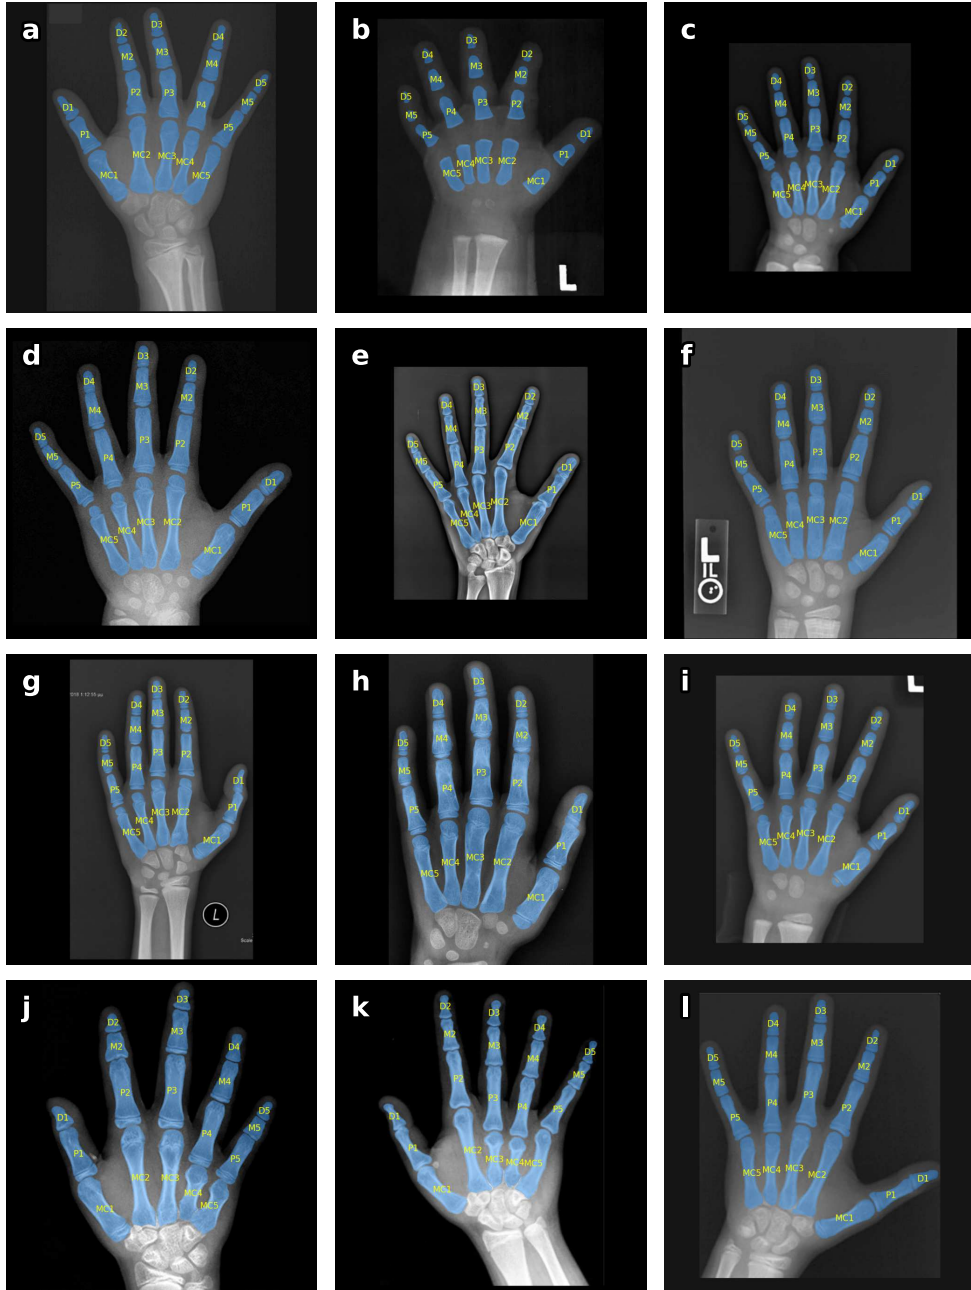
Examples of performance of InstanceSAM on dysmorphic hand X-rays. a: achondroplasia, b: Down syndrome, c: hypochondroplasia, d: Leri-Weill syndrome, e: Marfan syndrome, f: McCune–Albright syndrome, g: Noonan Syndrome, h: Ollier disease, i: Proteus syndrome, j: pseudohypoparathyroidism, k: pseudopseudohypoparathyroidism, l: Turner syndrome. The raw images are obtained via the GMDB [31], note the variations in scales and quality. MC: Metacarpal bone, P: Proximal phalanx, M: Middle phalanx, D: Distal phalanx.
